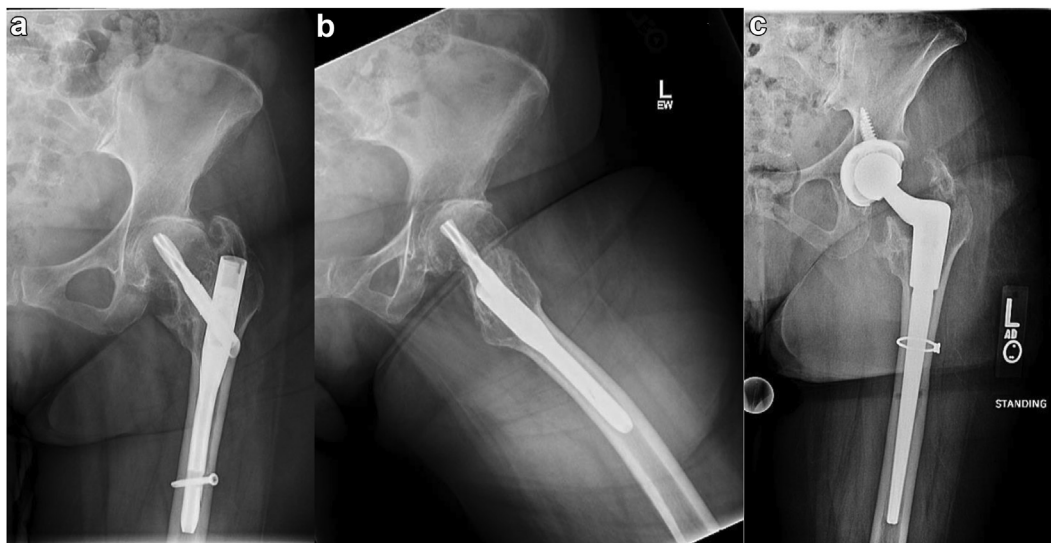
An 83-year-old female presented with posttraumatic arthritis 9 months after short Trochanteric Femoral Nail Advanced (Depuy Synthes) for an intertrochanteric fracture. AP (a) and frog-leg lateral (b) radiographs demonstrate from time of presentation. Intraoperatively, the left femoral neck had over 50 degrees of anteversion indicating malunion of the fracture. Postoperative AP radiograph (c) demonstrates an implanted diaphyseal-engaging stem for deformity correction.
